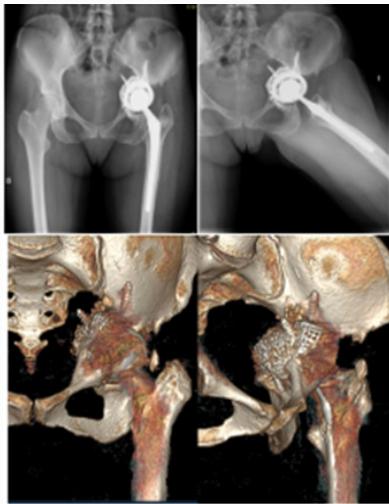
PA and axial hip radiographs and 3D reconstructions.
